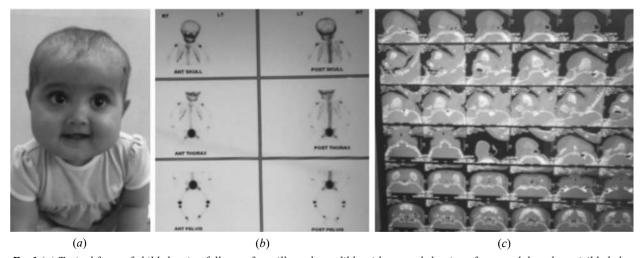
(a) Typical faces of child showing fullness of maxilla and mandible with upward slanting of eyes and the sclera visible below the irises; (b) Bone scan demonstrating increased uptake in the mandible and maxilla with no other abnormality; (c) CT scan of the child showing symmetrical enlargement of the mandibles.
